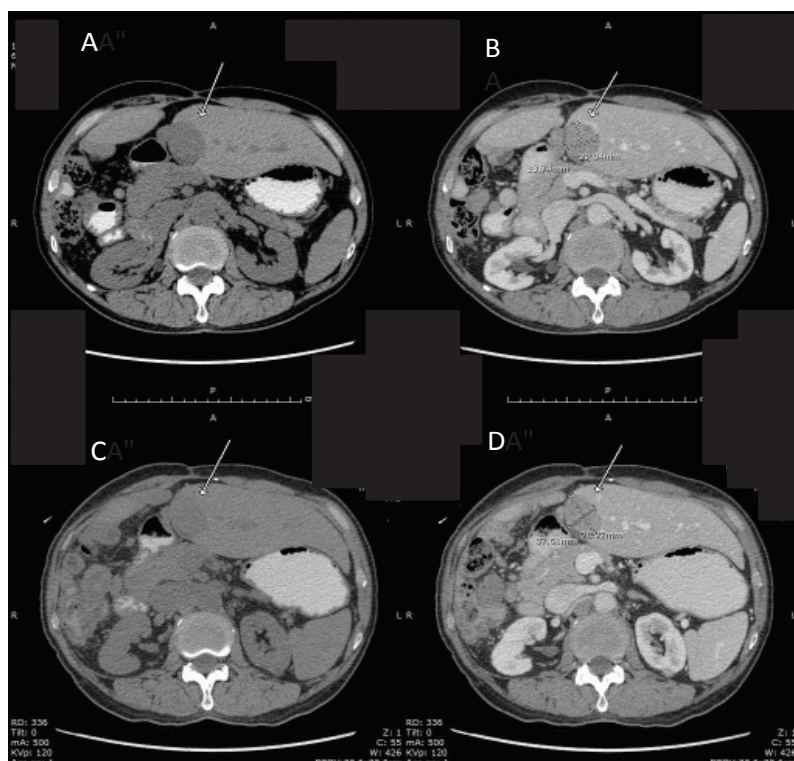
Stable disease in a 65-year-old male with mesenteric GIST; (a) Pre-treatment NECT (b) Pre-treatment CECT (c) Post-treatment NECT (d) Post-treatment CECT. Follow up CT showing an insignificant change of liver mass size and HU from 3.4x2.9 cm (40,81 HU) to 3.7x2.8 cm (42,83 HU) on NECT and CECT nearly 4 months after treatment, thus finding increased size and density of 9% and 5%, respectively, on NECT, and increased density of 2% on CECT.
